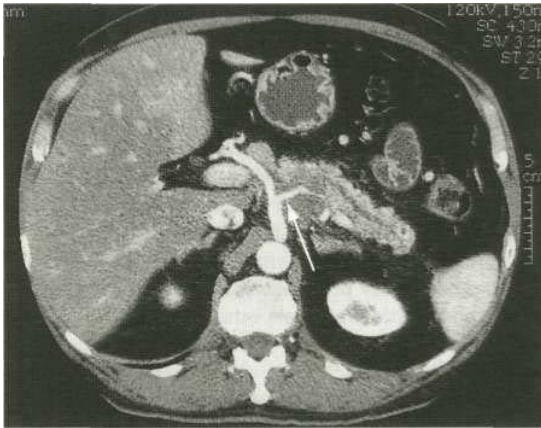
A contrast-enhanced CT scan showing a cancer of the body of the pancreas. There is retroperitoneal tumour extension enclosing the branches of the coeliac axis (arrow).
